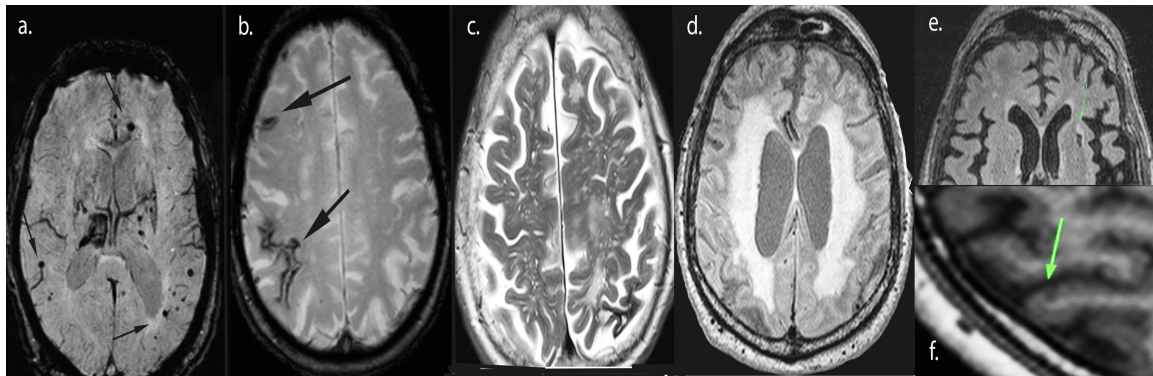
MRI markers of SVD, which are in order: a) Cerebral microbleeds b) Cortical superficial siderosis c) Enlarged perivascular spaces. d) White matter hyperintensities. e) Lacune. f) Cortical microinfarct.
